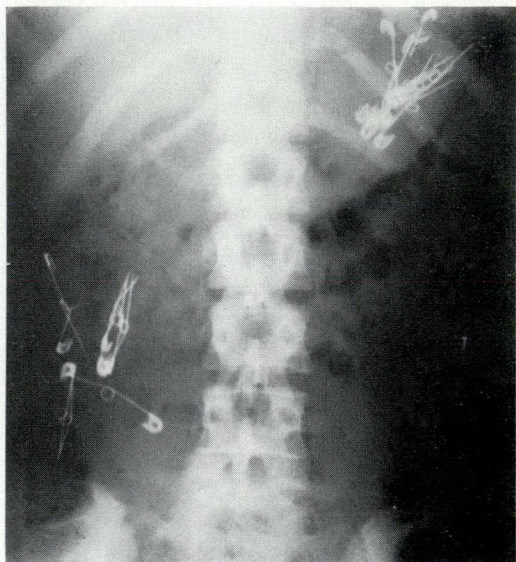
Radiograph taken on admission to the emergency department showing the distribution of the safety pins. There is no free air under the diaphragm.
